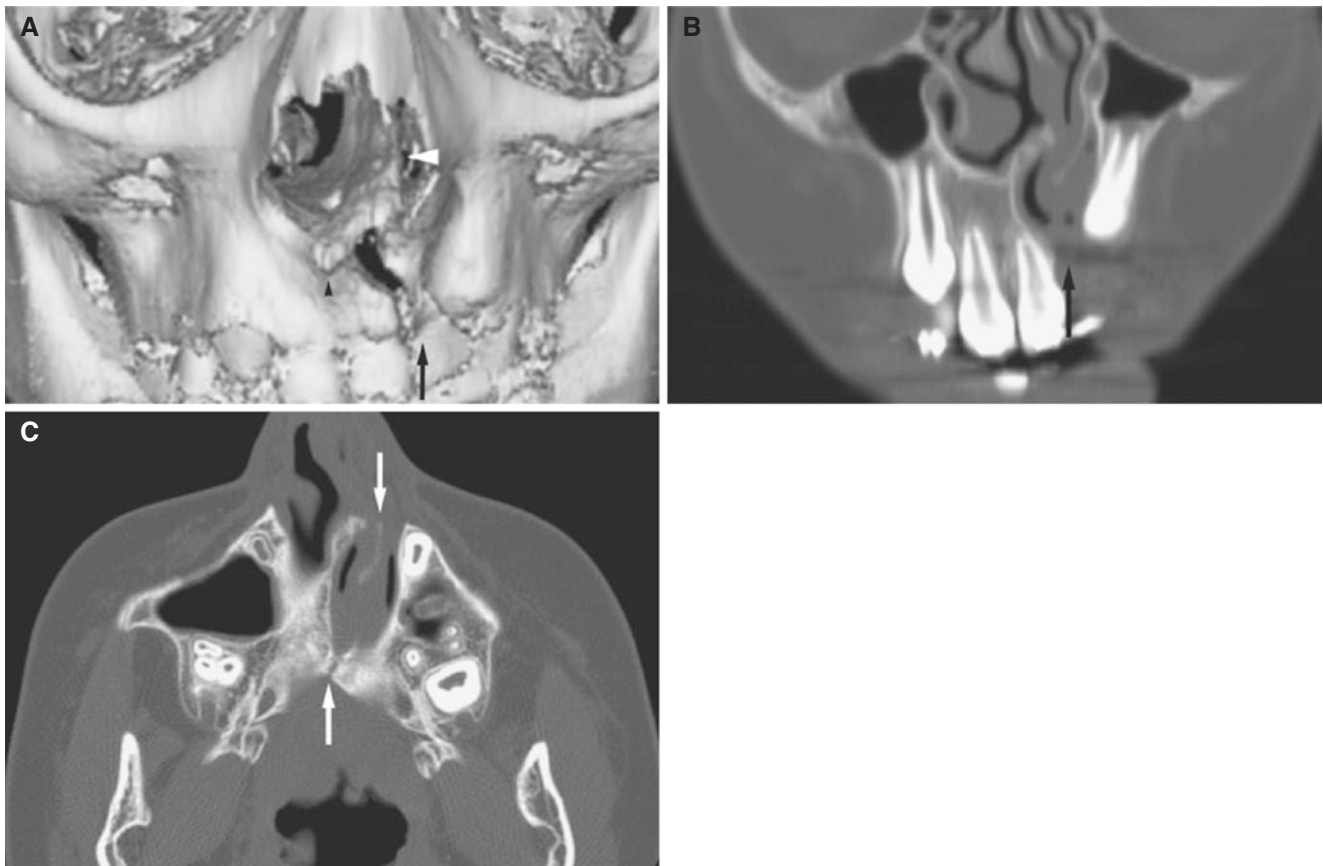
Cleft palate, unilateral; 11-year-old male with untreated deformity. (A) 3D CT image shows cleft on left side (*arrow*). Note the nasal septum deviating to the cleft side (*arrowhead*) and the anterior nasal spina (*small arrowhead*) deviating to the non-cleft side. (B)
